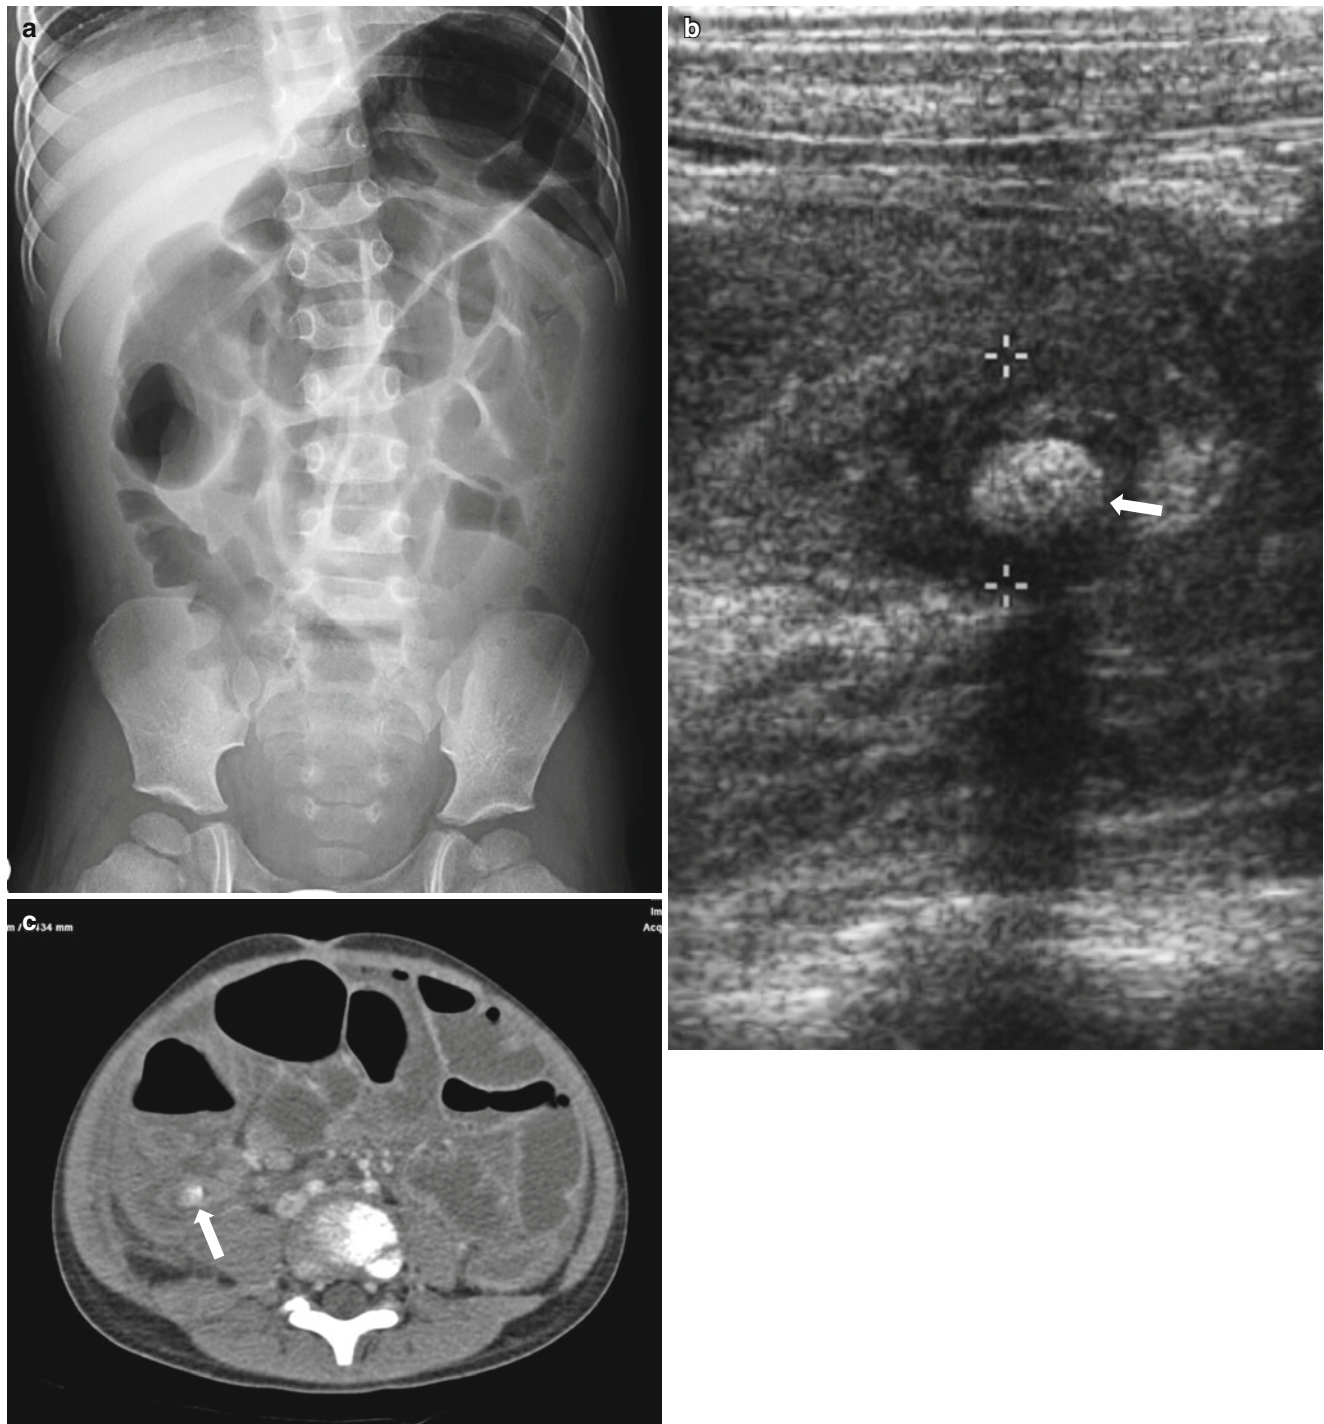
Perforated appendicitis in a 2-year-old boy with fever and abdominal pain. (a) Supine abdominal radiograph shows ileus and suspected bowel wall thickening, especially in RLQ. Appendicolith is not definitely identified. (b) US shows an appendicolith (*arrow*) surrounded by dirty fluid collection. It was difficult to define and trace
